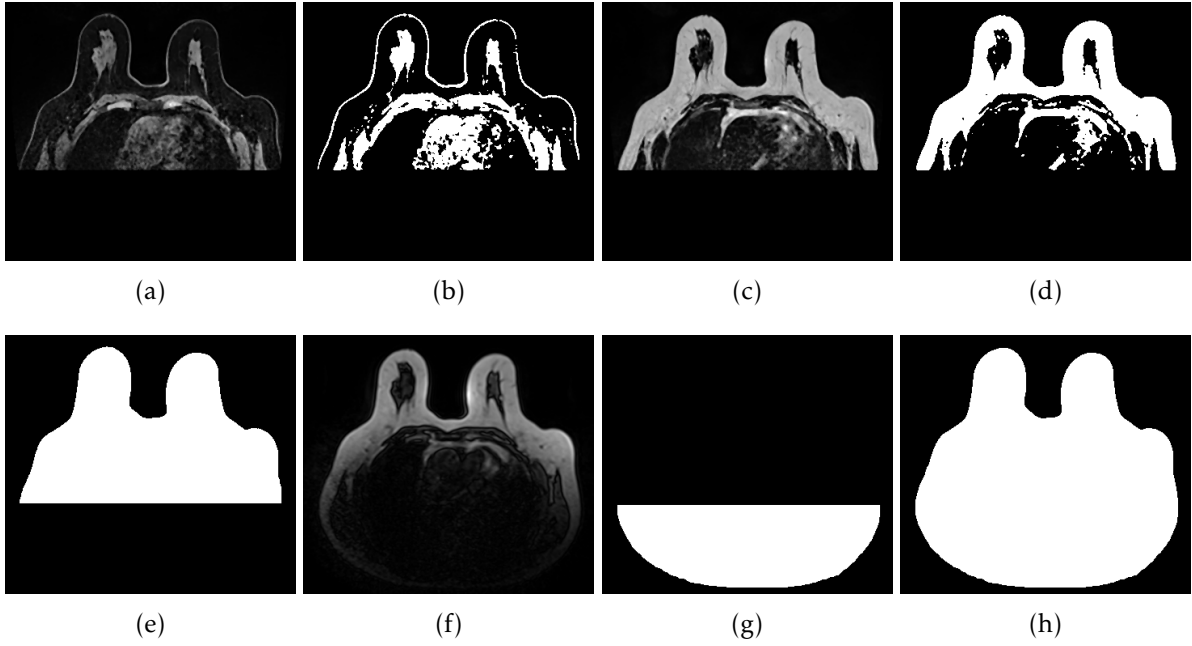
Example of background segmentation of an axial slice of a breast MR image. The images show (a) T₁-w Dixon-W and (c) T₁-w Dixon-F images, and the corresponding results of Otsu's thresholding in (b) and (d). The combination of (b) and (d) and after filling the holes within the body region result in (e). T₁-w localisation image is presented in (f) and the resulting image of the background segmentation is presented in (g). The final background is presented in (h), a combination of (e) and (g).
